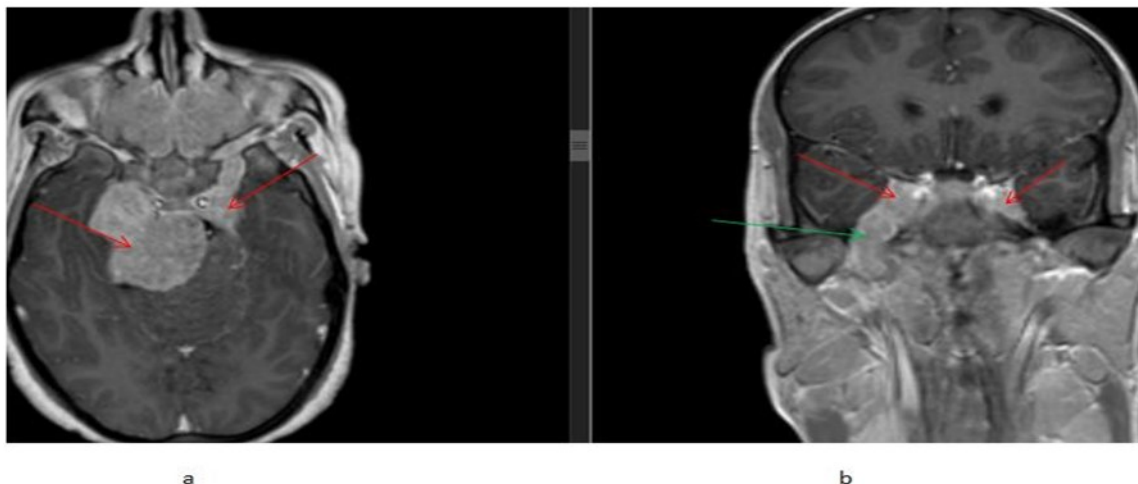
T1 post-contrast brain MRI, (a) axial and (b) coronal planes show multiple well-defined extra-axial dural based diffusely enhancing masses (red arrows) with extracranial extension through right foramen ovale (green arrow).
